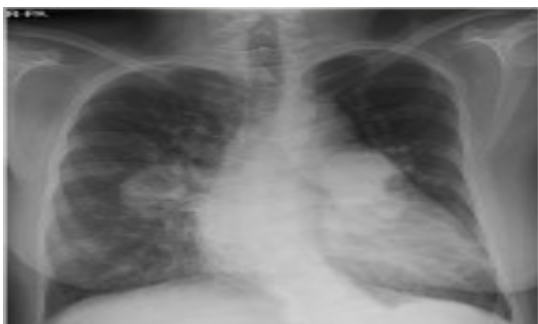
Chest radiograph showing cardiomegaly with pulmonary hypertensive changes
